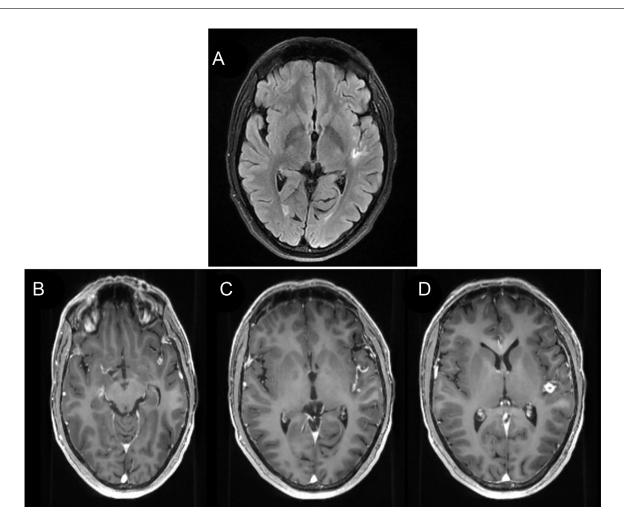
Final MRI Brain of patient taken a year after admission shows residual edema in the left peri–insular temporal lobe, as seen on (A) T2 FLAIR image. There is significant resolution of the left fronto-temporo-parietal insular subcortical leptomeningeal disease with residual ring enhancing lesions seen in the left peri–insular temporal lobe, as seen on (B-D) interval T1 postcontrast images.
